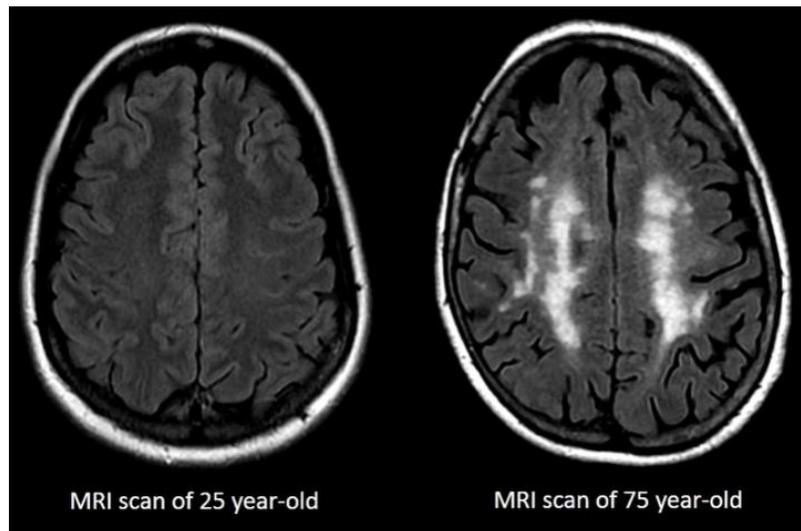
Two MRI scans from a young (left) and old (right) person, clearly showing the aging brain with a decrease in volume as a result of a degeneration of white matter causing white matter disease (the white color at the picture to the right). Obtained from a video presented at YouTube by Dr. Daniel Mandell, UHN Krembil Neuroscience Centre, Toronto.
